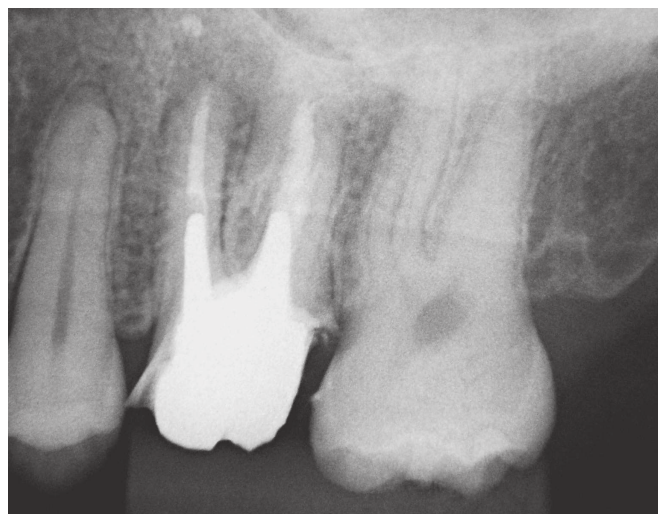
Diagnostic radiograph showing significant periapical lesion in the mesial root.
